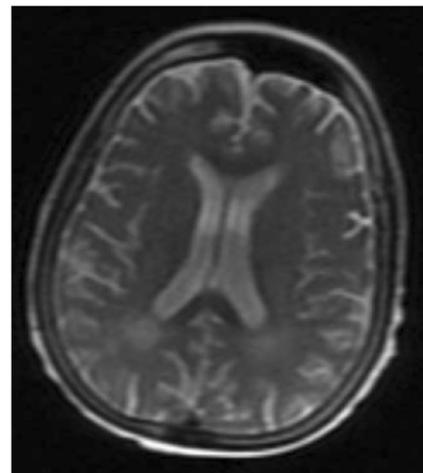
MRI brain of allo-SCT patient depicting T2 FLAIR hyperintense signal abnormalities involving periventricular white matter, concerning for leukoencephalopathy of underlying toxic metabolic causes
